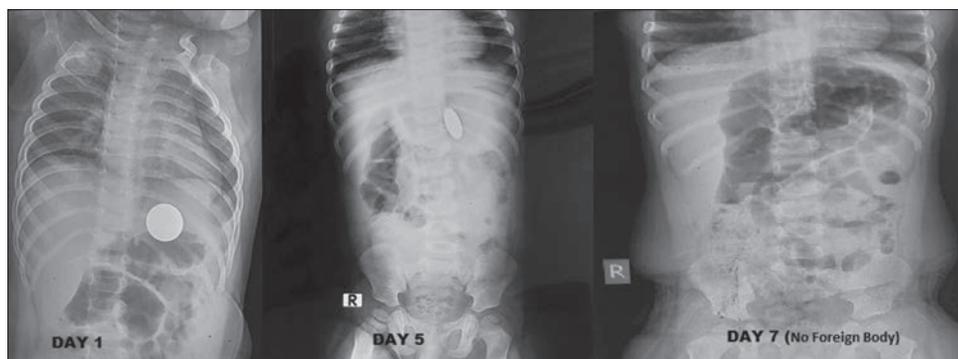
Serial X-rays showing change of positions of FB (coin) and spontaneous expulsion. FB: Foreign body
